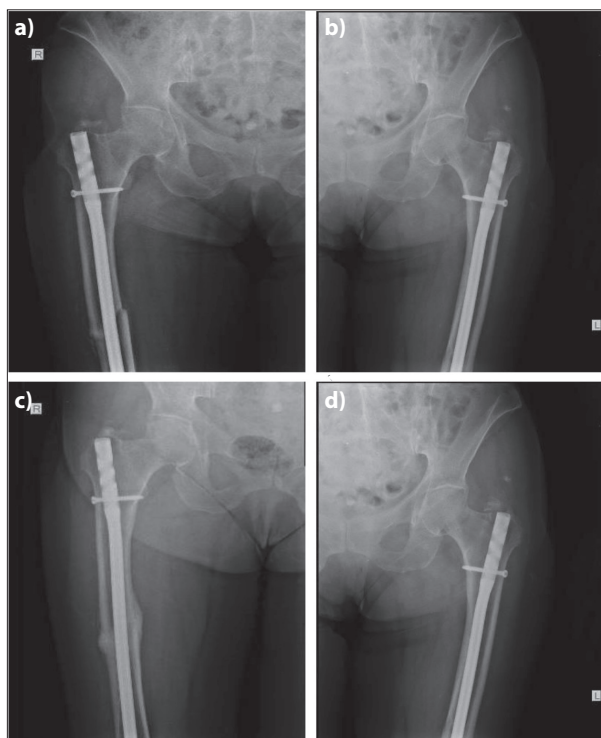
Radiographs showing the presence of early signs of healing six weeks after surgery [(a) and (b)] and complete union on both femurs four months postoperatively [(c) and (d)]
